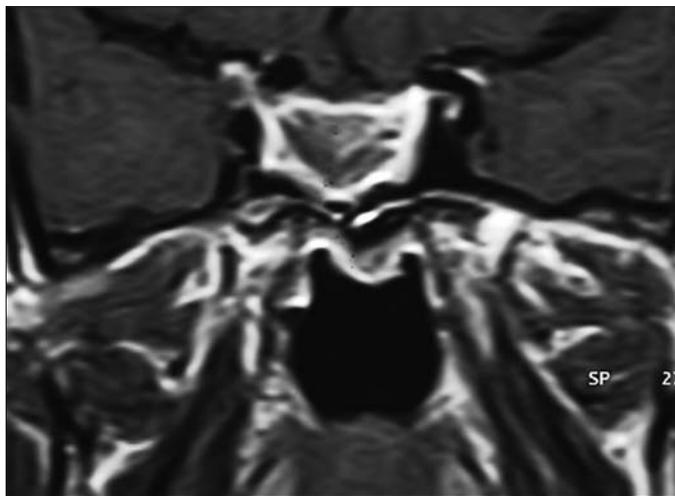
In the 10th postoperative year, there is necrotic appearance of a 3x2.5 cm mass, and peripheral rim shaped enhancement on coronal T1 weighted contrast MR image.
